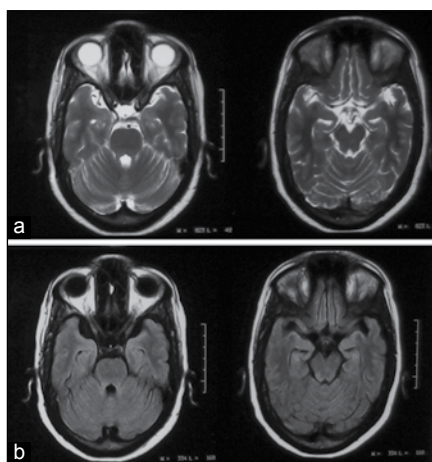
Repeat MRI brain T2-weighted (a) and FLAIR (b) sequences showing disappearance of brainstem hyperintensities after treatment
